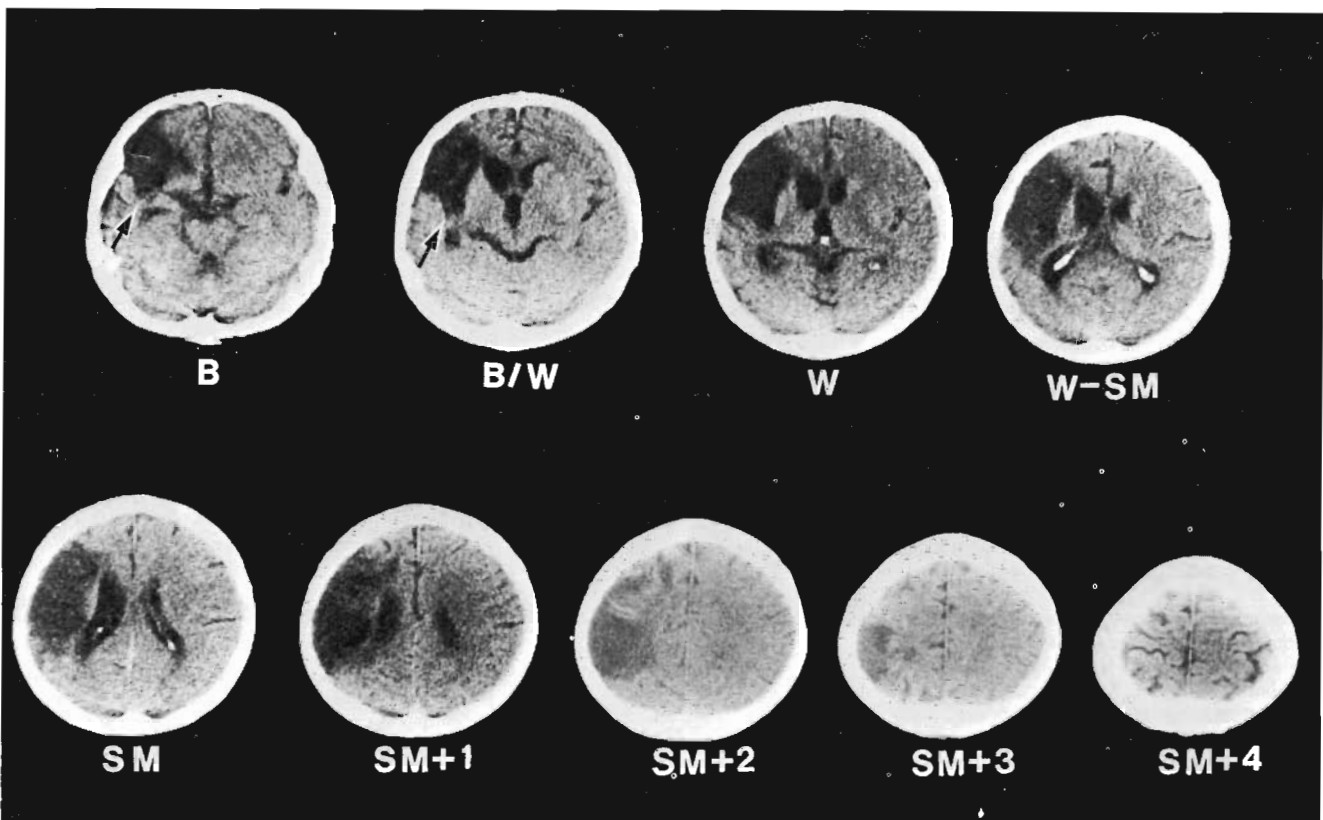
Top, Computed tomographic scan at 33 months post onset (MPO) of an FPTi case, case 11 (age, 61 years), showing extensive cortical/subcortical lesion in the frontal and parietal lobes, but only subcortical temporal lobe lesion in the temporal isthmus at slices B and B/W (arrows). Note complete sparing of Wernicke's cortical area on slices B/W and W. Bottom, Graph showing this patient's Boston Diagnostic Aphasia Examination (BDAE) Auditory Comprehension Z scores over a period of several months post onset. Note good recovery of auditory comprehension beginning at 2 to 4 MPO. His BDAE Auditory Comprehension Z scores were -0.24 , -0.33 , and -0.18 at 14, 33, and 54 MPO, respectively.
